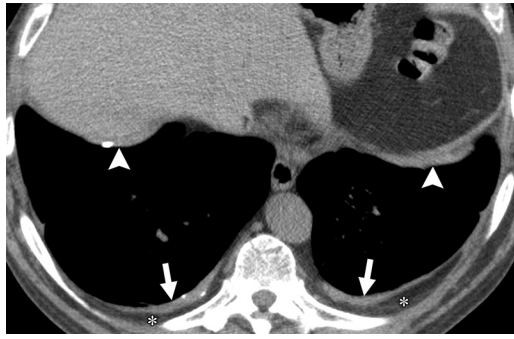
Extrapleural adipose tissue thickening associated with pleural plaques. Axial targeted reconstruction CT image of the posterior region of the chest shows increased extrapleural adipose tissue (*) adjacent to pleural plaques in the posterolateral parietal pleural surfaces (arrows) and dome of the diaphragm (arrowheads). The plaques are secondary to asbestos exposure. The finding of increased extrapleural adipose tissue is useful for determining the chronicity and benign cause of the pleural abnormality.
